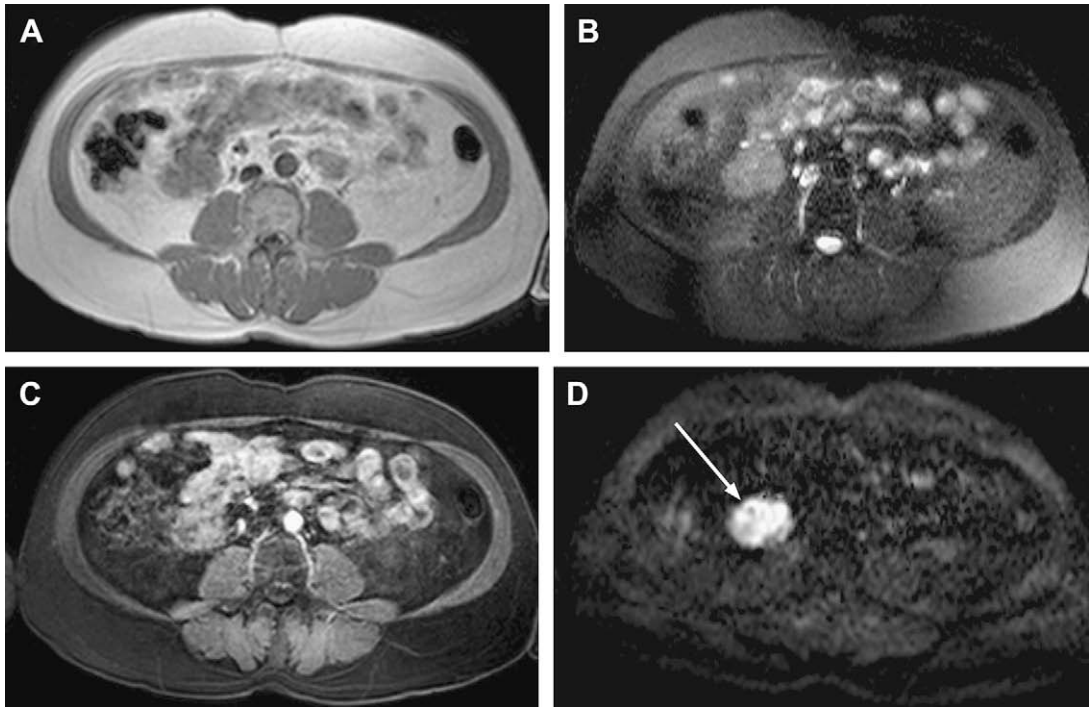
68-year-old man with prostate cancer and rising PSA. T1-weighted (A), T2-weighted (B), and fat suppressed gadolinium-enhanced SGE (C) images were interpreted as showing unopacified bowel but no evidence of tumor. Breath hold DWI (D) b-value 500 s/mm² shows a 3 cm right-sided retroperitoneal tumor (arrow).
